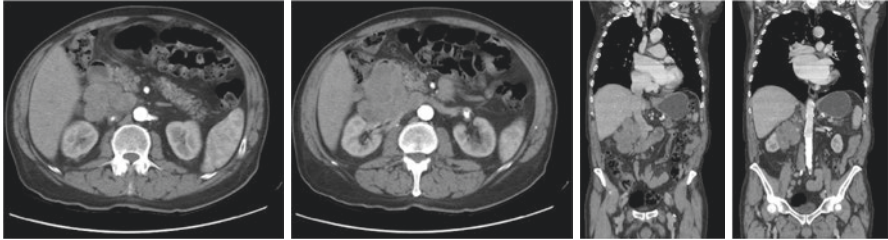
Case 1 – A 48-year-old female patient complaining of postprandial packing. CT shows a retroperitoneal mass displacing the structures of the hepatic hilum, with possible involvement of the duodenal-pancreatic sulcus, compressing and displacing the right renal vein. It is difficult to distinguish between a primary tumor of a retroperitoneal organ and a primary tumor of the retroperitoneal space. Upper gastrointestinal endoscopy demonstrated the duodenal involvement. Definitive diagnosis was done during the surgery. It was a leiomyosarcoma primary of the vena cava. Case 2 – A 78-year-old male patient complaining of abdominal pain in the right hypochondrium and melena. CT shows an expansive and heterogeneous solid lesion, with lobulated contours, located on the posterior wall of the second portion of the duodenum, with extensive posterior expansive component. Note the compression and displacement of the inferior vena cava and the renal vessels on the right. Echo-endoscopy biopsy revealed the diagnosis of duodenal GIST
